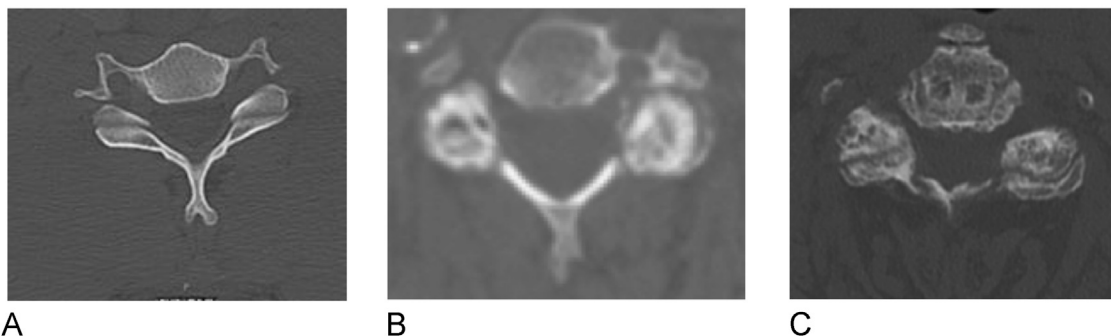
CT scan obtained to evaluate for (A) no facet arthrosis, (B) mild facet arthrosis, and (C) severe facet arthrosis. (Adapted with permission from K. Daniel Riew, MD.)
